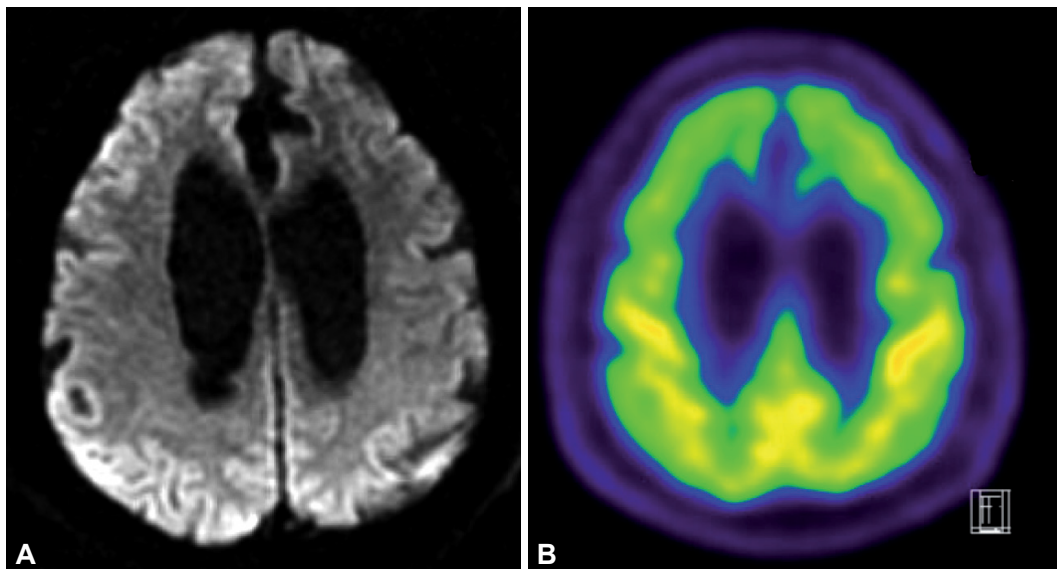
Initial DWI and 18F-fluorodeoxyglucose PET CT. A: DWI demonstrates cortical high-signals. B: PET study shows diffuse hypometabolism of bilateral frontoparietal lobes. DWI: diffusion weighted image, PET: positron emission tomography.
